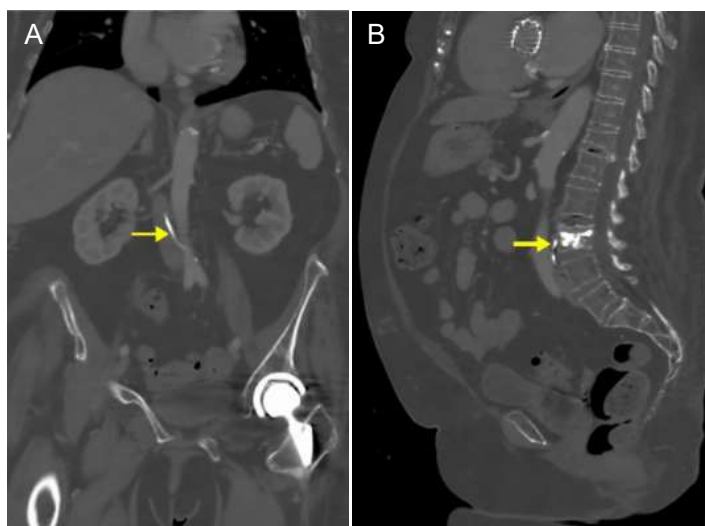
A) Coronal and B) sagittal contrast-enhanced computed tomography of the abdomen and pelvis demonstrating linear hyperdense cement extending from the third lumbar vertebral augmentation site into the inferior vena cava (arrow), concerning for intravascular cement migration.
